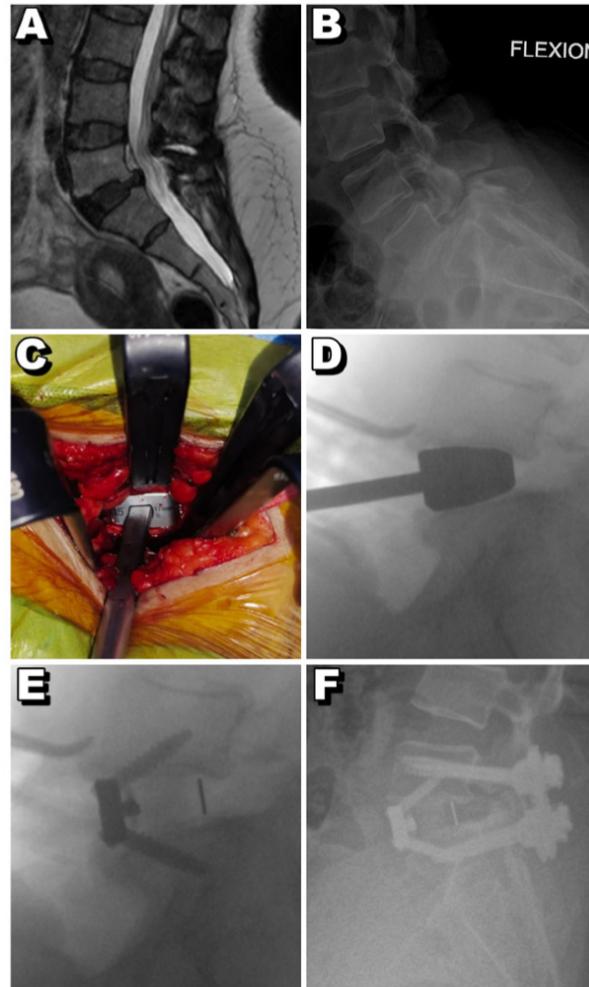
Clinical case example of L5-S1 ALIF with posterior percutaneous pedicle screw fixation. (A) Pre-operative T2W sagittal MRI image showing a wedge-shaped L5-S1 disc space with restored alignment [compared to standing X-ray (B)]. (B) Pre-operative standing flexion lateral radiograph showing an unstable L5-S1 spondylolisthesis. (C) Intra-operative anterior retroperitoneal exposure to the L5-S1 disc space with retractors in place and trial inserted in to the disc space. (D) Lateral intra-operative fluoroscopic image showing the trial cage in place. (E) Lateral intra-operative fluoroscopic image after planning the final cage and screws (inserted through slots in the cage) achieving complete reduction of listhesis. (F) Final lateral post-operative radiograph showing the anterior cage with screws along with posterior percutaneous screws.
